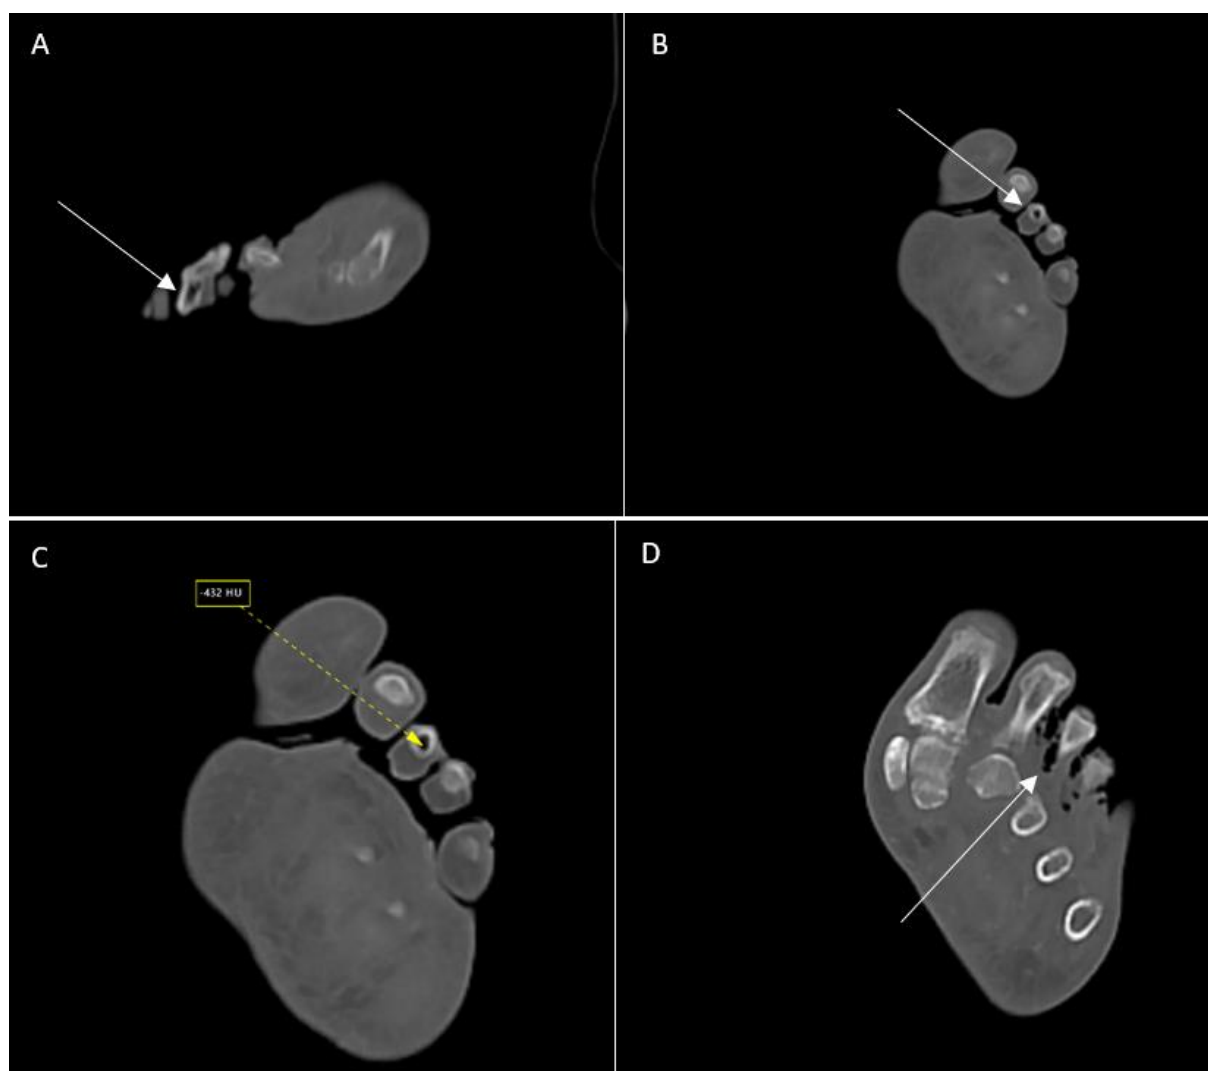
(A) Sagittal reconstruction in bone window during the arterial phase showing multiple intramedullary gas locules within the distal phalanx of the third toe. (B) Axial bone-window image in the arterial phase demonstrating the same intraosseous gas foci within the third toe. (C) Axial arterial-phase CT confirming that the attenuation of these locules is consistent with gas density. (D) Axial bone-window image revealing gas bubbles within the surrounding soft tissues, associated with overlying skin loss.
